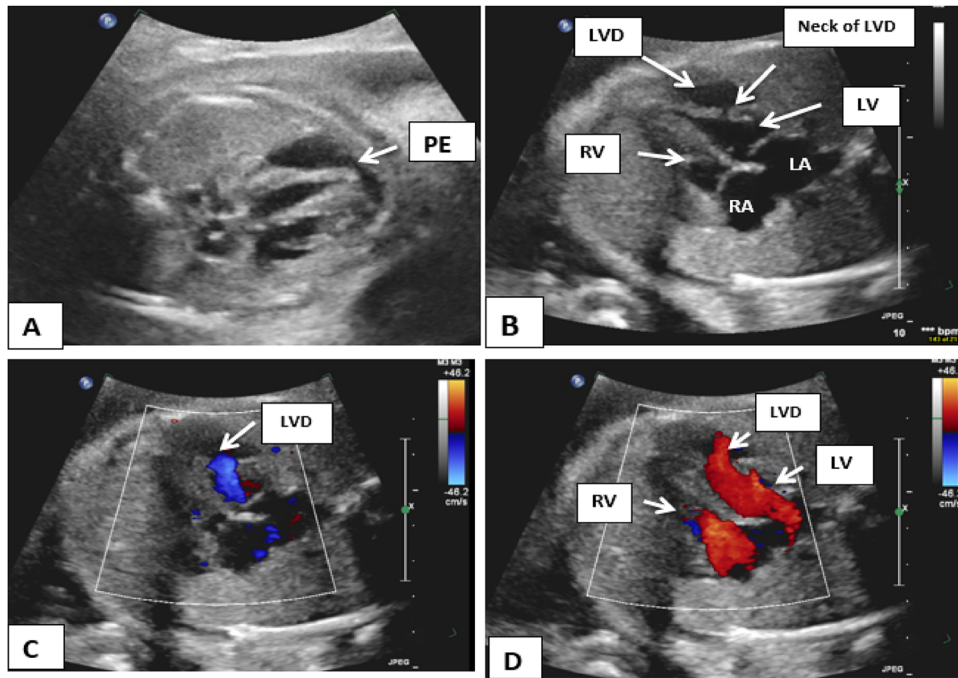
2D and color Doppler echocardiographic images of four chamber views of twin A fetal heart at 30 weeks gestation demonstrating A moderate pericardial effusion (PE). B Large left ventricular diverticulum from the posterolateral LV wall (LVD) with the neck of this diverticulum. C, D showing blood flow from left ventricle (LV)
